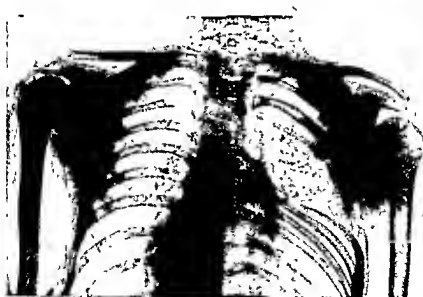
Radiograph of Sprengel's Deformity, showing also congenital deformities of ribs and wedge vertebrae.
